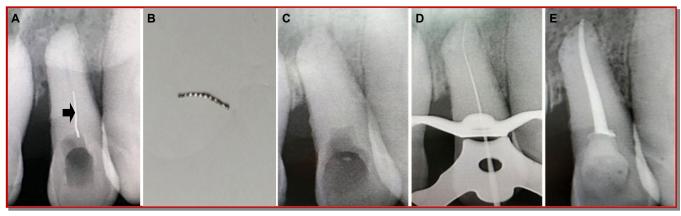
Pre-operative radiograph shows a broken instrument (arrow) within the canal (A); Photograph of separated instrument (B); Following retrieval of the instrument, root canal was patent (C); a K-file was inserted into the canal for working length determination (D); Canal obturation with protaper gutta-percha and sealer (E)
